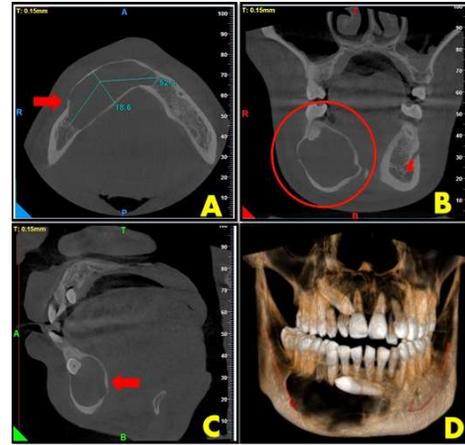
A- AXIAL, B- CORONAL, C- SAGITTAL, D- 3D RECONSTRUCTION VIEW OF CBCT
